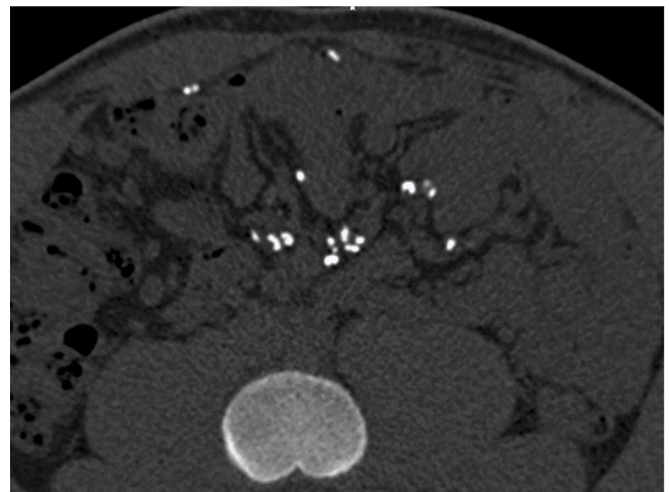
Unenhanced CT scan demonstrating multiple «comma-shaped» calcifications located in the peritoneal cavity.
